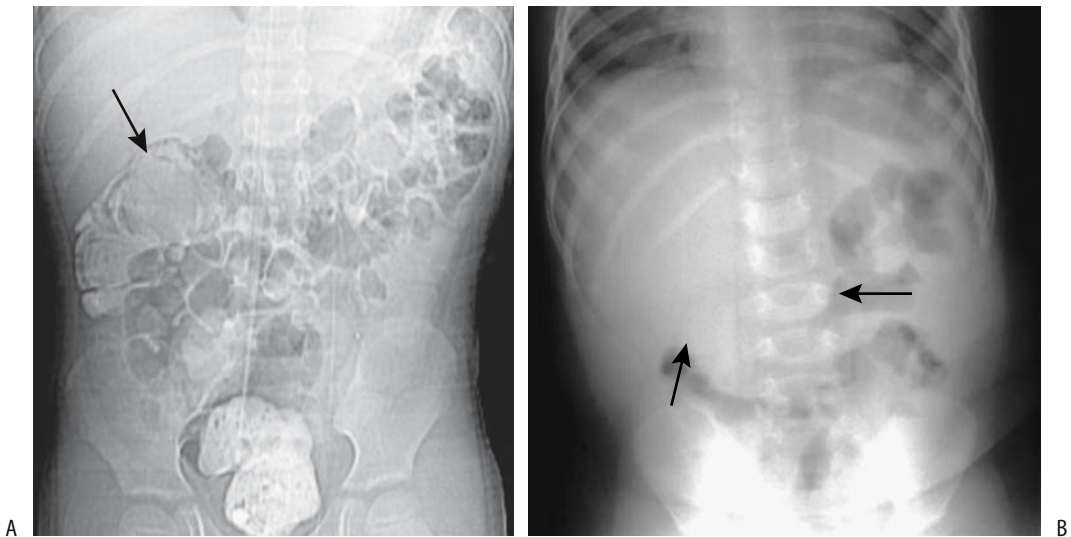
Ileocolic intussusception. A: CT scout view identifies an intussusception (arrow) in a 7-year-old. Burkitt's lymphoma was the lead point. (Courtesy of Luann Teschmacher, M.D., University of Rochester.) B: Intussusception in a 10-month-old infant with pain and palpable right upper quadrant mass. A conventional radiograph reveals a soft-tissue tumor in region of transverse colon (arrows). A barium enema confirmed intussusception.
